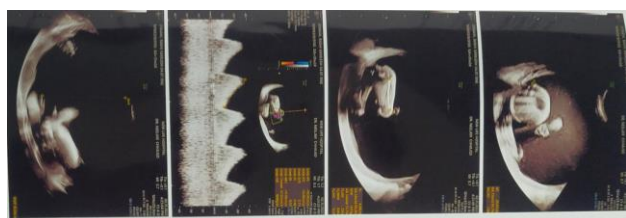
AFI: 54-55 cm (SDP-18.29 cm) with normal Doppler analysis at 31 weeks of gestation.
